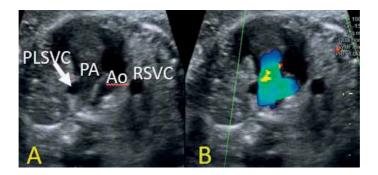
Persistent left superior vena cava (PLSCV), indicated with arrow in duplex gray-scale (A) and color Doppler (B) evaluation.
